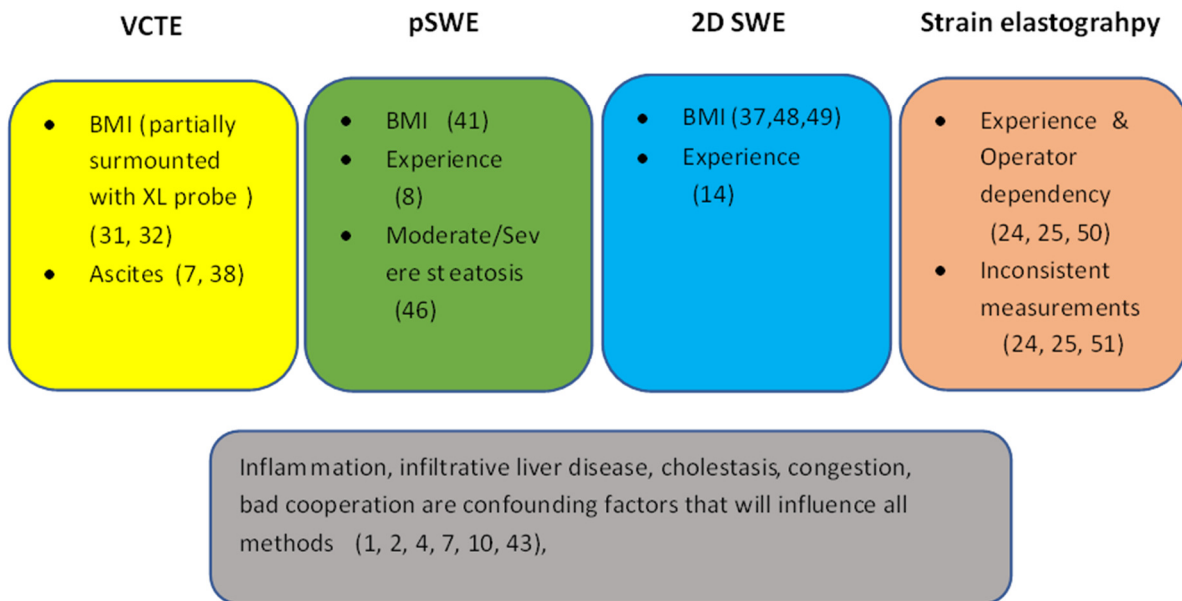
Confounding factors associated in ultrasound-based elastography
